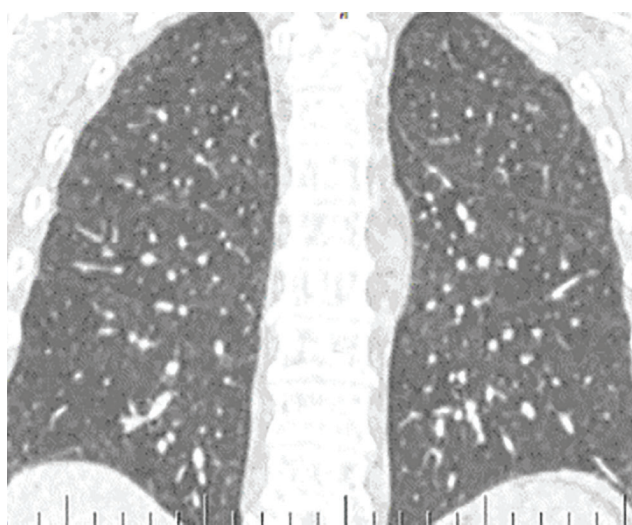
A, B. A — axial projection, B — frontal projection of CT of the chest organs before surgery. There are multiple areas of frosted glass darkening in the left lung
